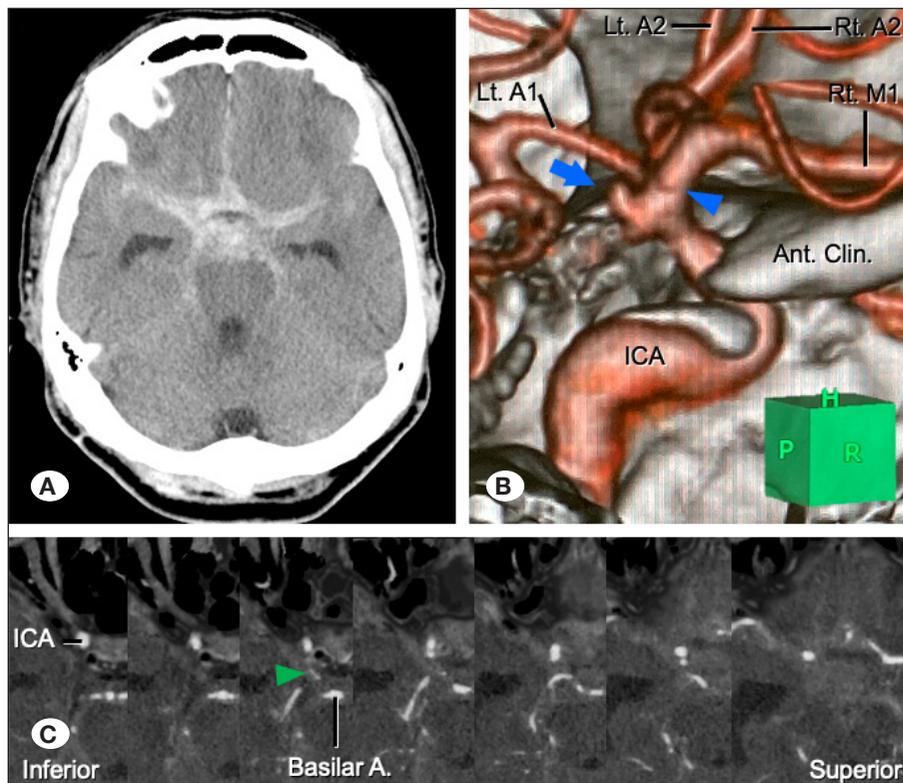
Preoperative neuroradiological examinations. A) Axial plane computed tomography (CT) image showing subarachnoid hemorrhage in the basal cistern and bilateral sylvian fissures, and mild hydrocephalus. B) Reconstructed CT angiography image shows a double-hump aneurysm originating from the posterior wall of the right ICA (blue arrow). Although the posterior communicating artery (PComA) was not identified, a diagnosis of PComA aneurysm was made because a small ridge that appeared to be the origin of the anterior choroidal artery was identified distally (blue arrowhead). C) The origin of the PComA is not clearly depicted on serial axial digital-subtracted CT angiographic images. Only approximately half of the vessels in the distal portion, which appeared to be PComA, were confirmed (green arrowhead). A: Artery; Ant: Anterior; Clin: Clinoid; ICA: Internal carotid artery; Lt: left; Rt: right.
